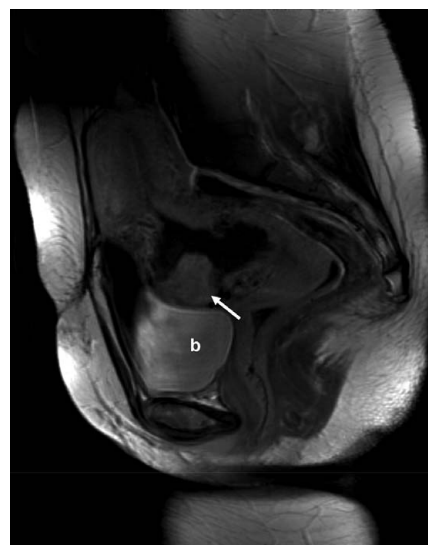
Magnetic resonance imaging showed a 2.7×2.3 cm mass within the same location suggestive of placenta increta (arrow). b = bladder.
